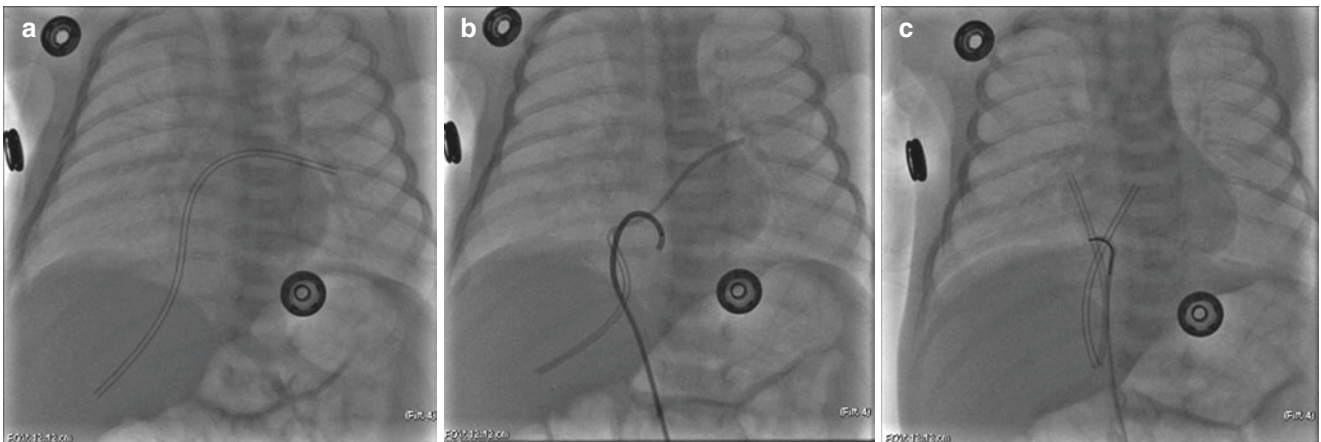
Indwelling umbilical venous catheter migration. A 10-day-old premature baby (2.2 kg) was transferred to our cath lab after an accidental migration of an indwelling umbilical venous catheter (UVC). On chest X-ray, the UVC was stuck between the hepatic vein and the right pulmonary vein through the PFO (a). Through a 5 F short venous
